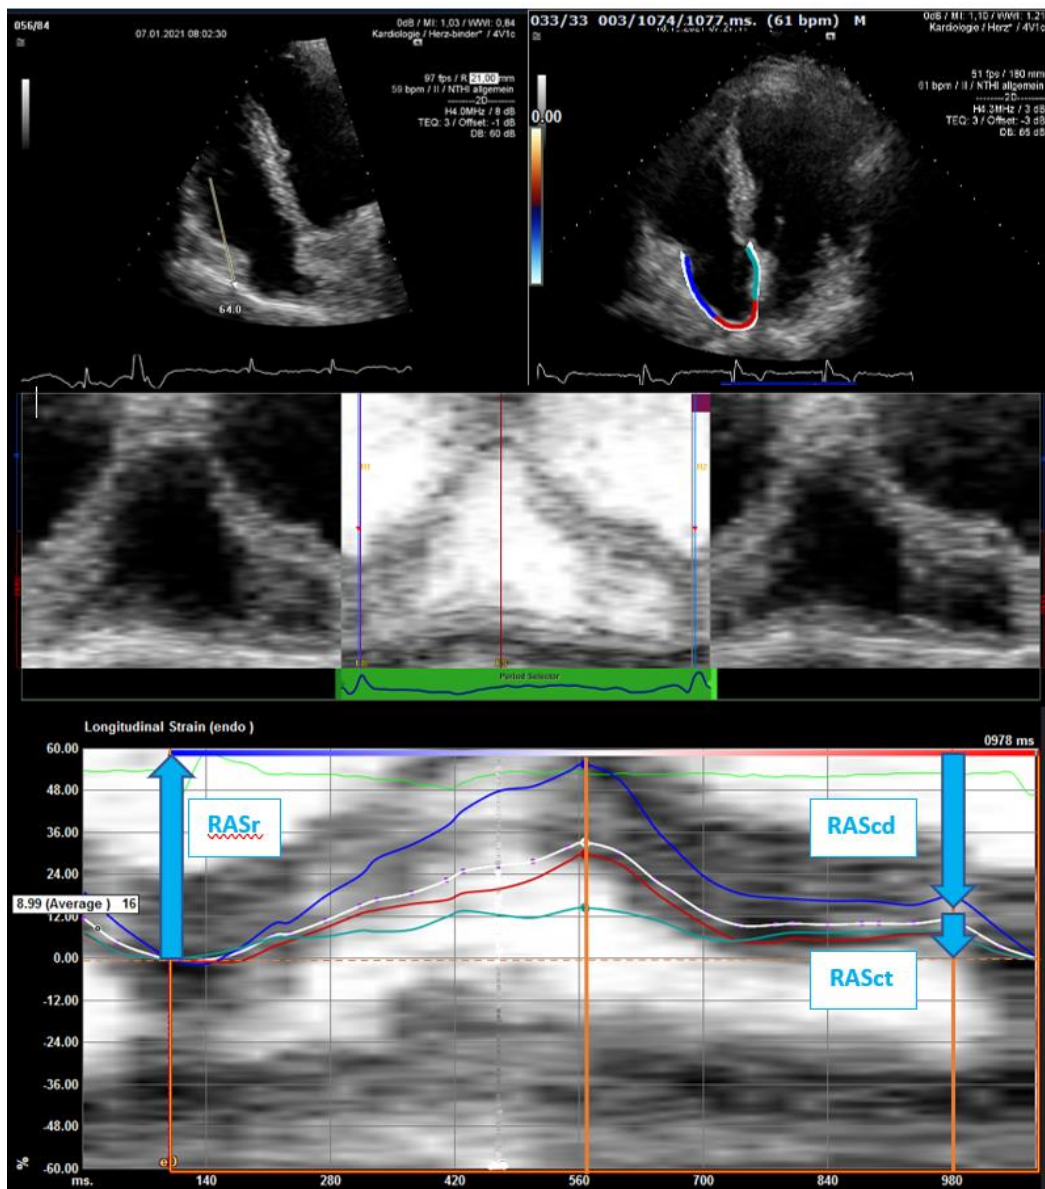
Example of right atrial strain and functional phasis in RV-focused apical four-chamber view using the software TomTec, RASr = strain during reservoir phase, RAScd = strain during conduit phase, RASct = strain during contraction phase.
